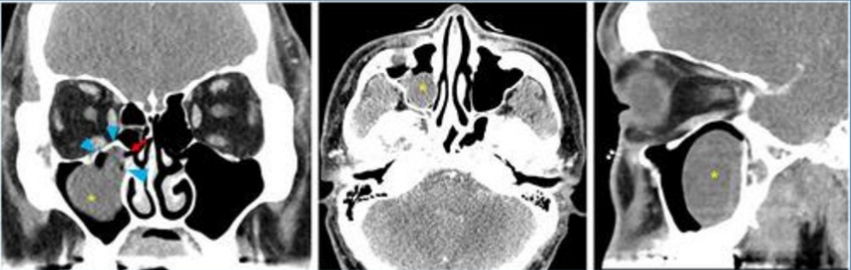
CT sinus imaging showing a maxillary retention cyst with signs of rupture, as indicated by its scalloped edges⁵
